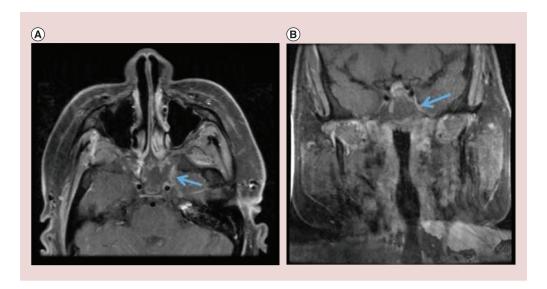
MRI head: intracranial dural involvement – postcontrast T1-weighted images show asymmetric dural thickening in inferomedial left middle cranial fossa, adjacent to cavernous sinus and Meckel's cave.
